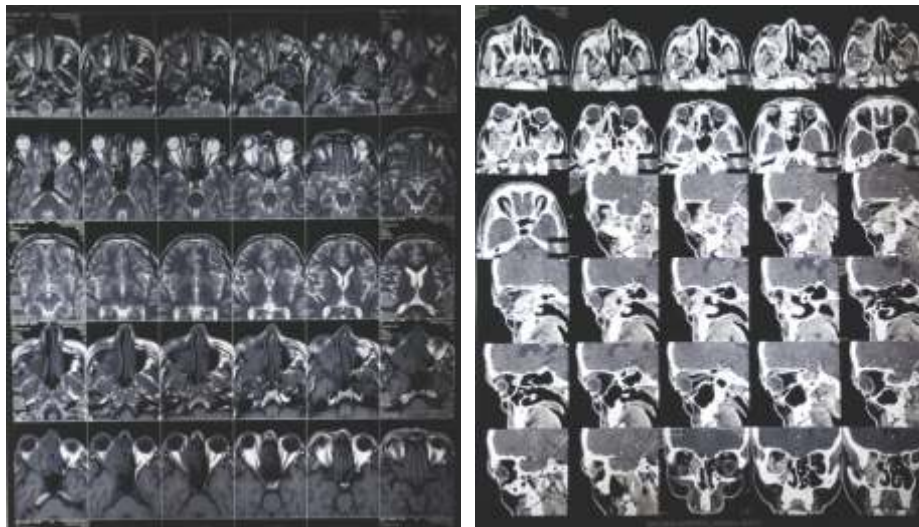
Pre Operative CT Scan Showing Hypodense in the Right Maxillary Sinus
